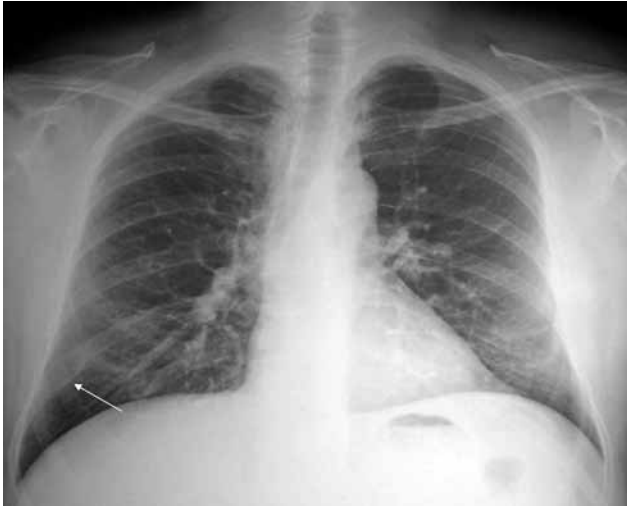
Chest X-ray revealed a mass-like opacity on the right ninth rib.
